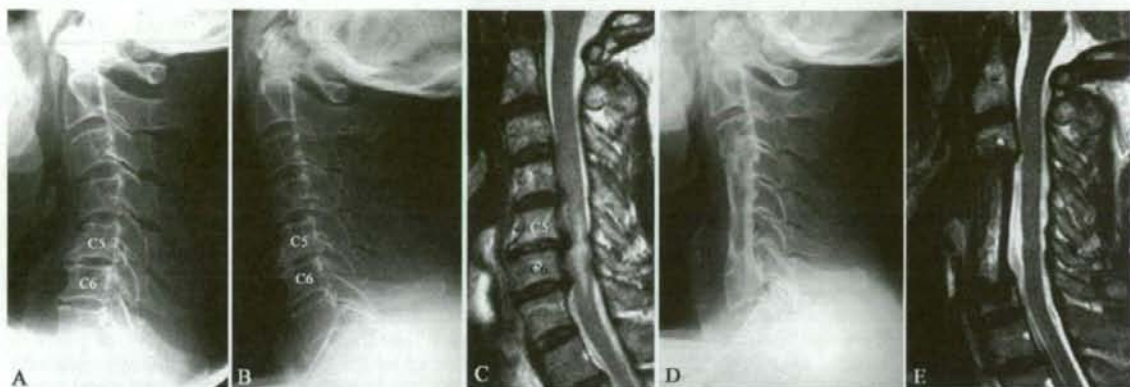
Case 3. Flexion (A) and extension (B) cervical radiographs obtained at the initial visit in a patient with segmental-type OPLL. The residual space available for the cord was 10 mm at the C5–6 level, and the C1–7 ROM was 57°. A T2-weighted midsagittal MR image (C) obtained at presentation shows impingement on the spinal cord at multiple levels in both the anterior and posterior directions, and HSCs are evident in the spinal cord, especially at C5–6 and C6–7. Lateral cervical radiograph (D) obtained 2 years after surgery shows successful spinal fusion with fibula autograft. A T2-weighted midsagittal MR image obtained 1 year postoperatively (E) shows decompression and diminished cord HSCs.
